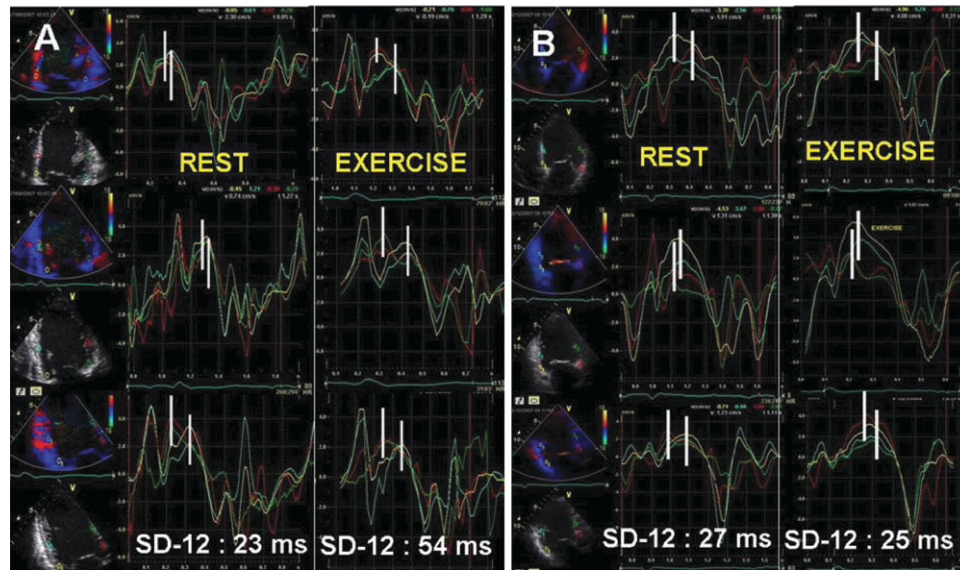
Tissue Doppler imaging echocardiograms depicting exercise-induced changes in systolic dyssynchrony index being estimated as the standard deviation of the time-to-peak systolic velocities of the 12 LV segments (SD-12). (A) A patient with an increase in dyssynchrony index; (B) a patient without significant change in dyssynchrony index.
